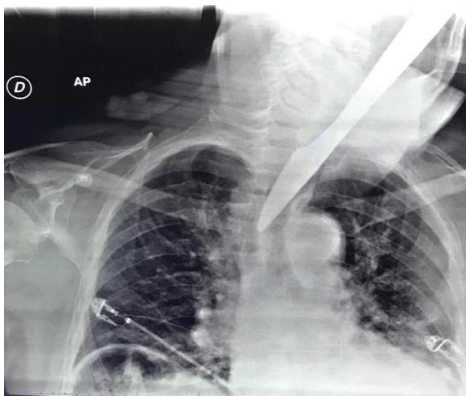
X-ray where we can see the knife following a trajectory from left to right, down to the region of the mediastinum.
